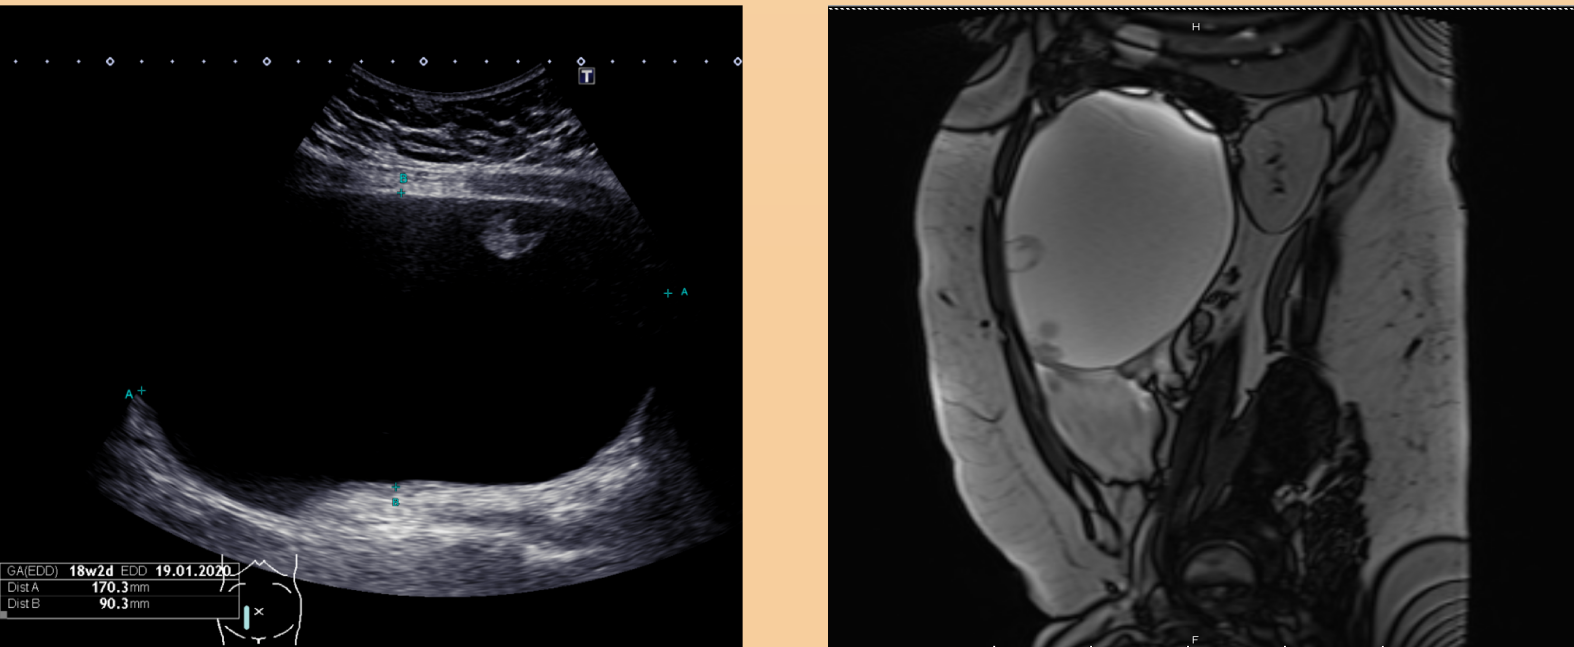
Left: Ultrasound at 11 weeks gestation showing a large cystic mass with a solid nodule. Right: MRI coronal T2 image at 20 weeks gestation showing 2 solid nodules within the mass.
